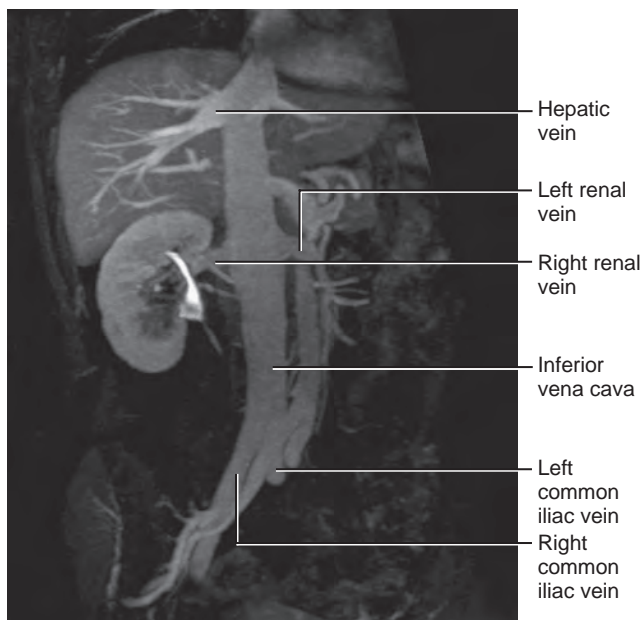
Radiograph showing inferior vena cava and its tributaries. (From MacLennan GT. *Hinman's atlas of urosurgical anatomy*. 2nd ed. Philadelphia: Saunders; 2012.)
